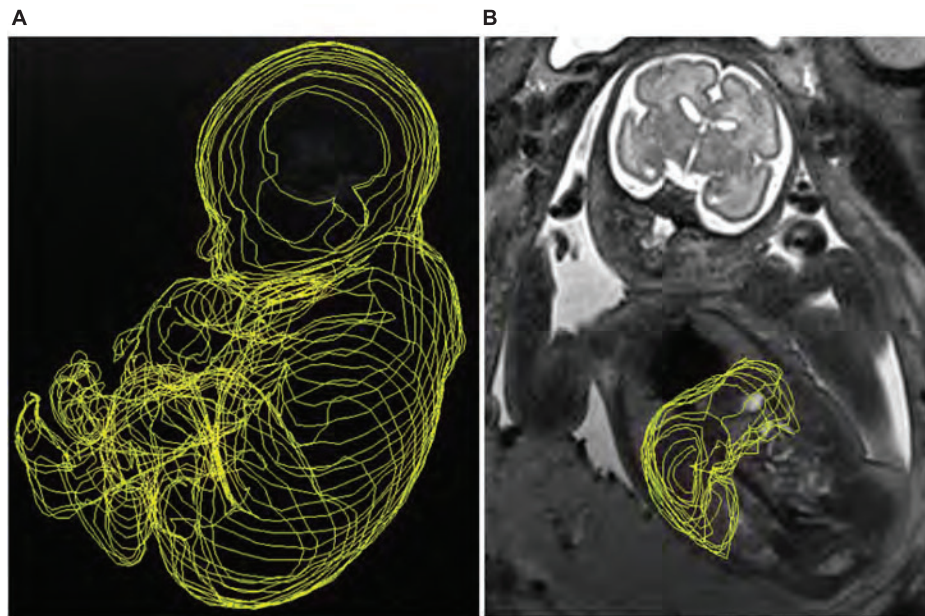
(A) Manual tracing of the total fetal body obtained from a T2-weighted imaging sequence in sagittal view. (B) Manual tracing image of the fetal liver volume obtained from a T2-weighted imaging sequence in coronal view.
